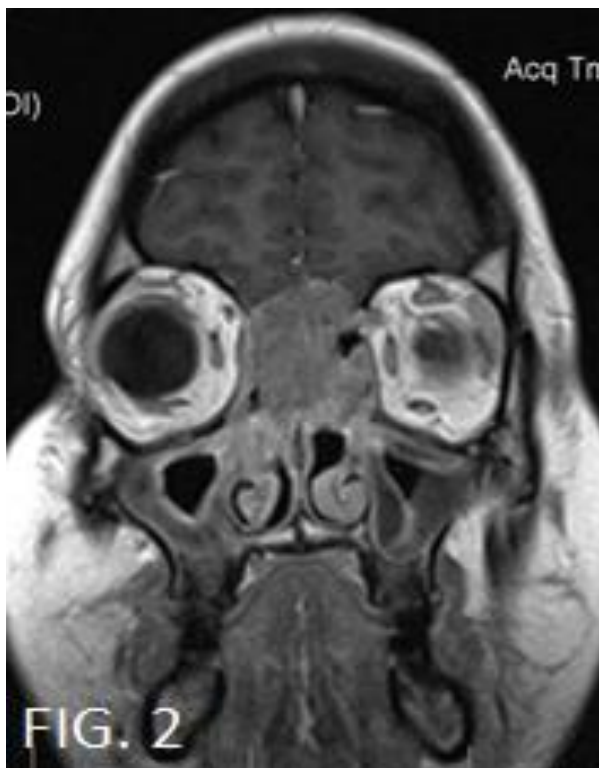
MRI Cor Gd-T1WI.
